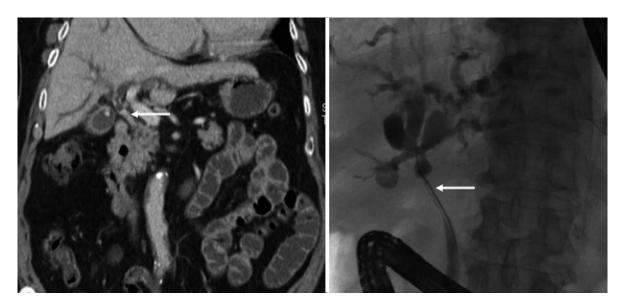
Coronal reformatted CT image (*left*) shows enhancing mass (*arrow*) in common hepatic duct obstructing the duct and causing jaundice. Findings are most consistent with cholangiocarcinoma. ERCP image (*right*) confirms stricture which was proven to be a cholangiocarcinoma at surgery
